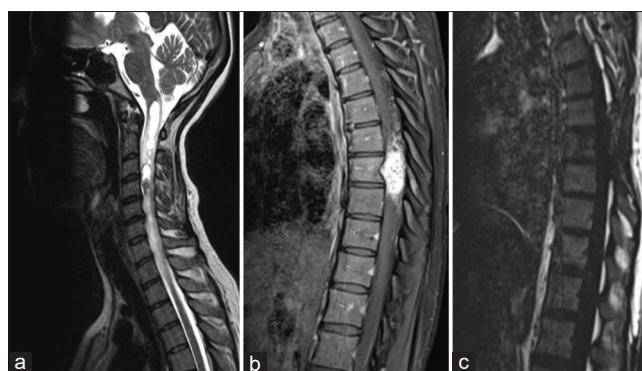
(a) T2-sagittal magnetic resonance image of the cervical spine with a nodule at the C4 level with syrinx extending up to the medullary region level. (b) Gadolinium-enhanced sagittal Magnetic resonance image showing a brilliantly enhancing lesion at the T8 level with scalloping of the T8 vertebral body. (c) Gadolinium-enhanced sagittal Magnetic resonance image taken on postoperative day 1 showing complete excision of the lesion with no residual enhancement
